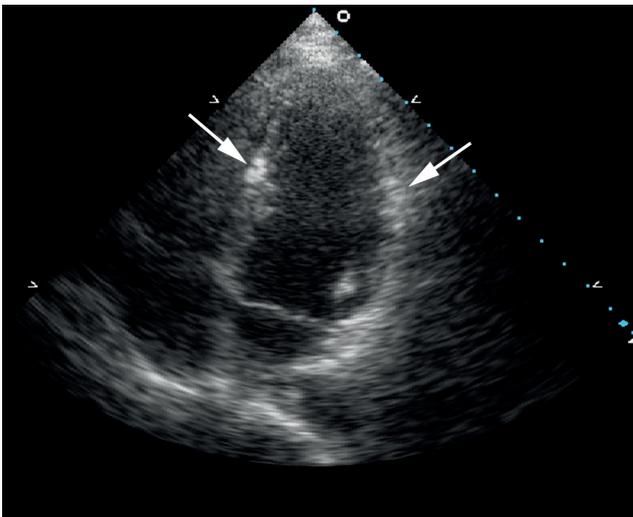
Echocardiogram (4-chamber view) of a 23-year-old woman with tuberous sclerosis complex shows 2 focal areas of increased echogenicity; 1 in the interventricular septum (left arrow) and 1 in the left ventricular wall (right arrow).
